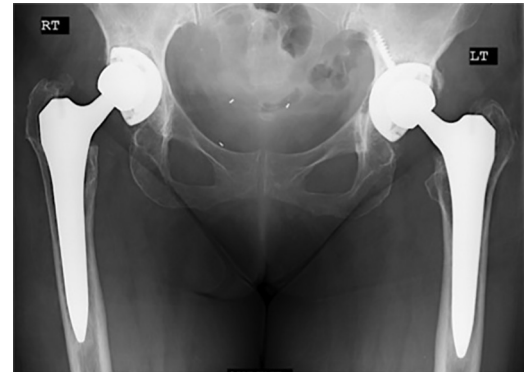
Pelvic Anterior-Posterior radiograph of patient at 30 months status post-Primary THAs. Note the medial wall thinning of the acetabulum and subsidence on the left side and increased cup inclination on the right.
